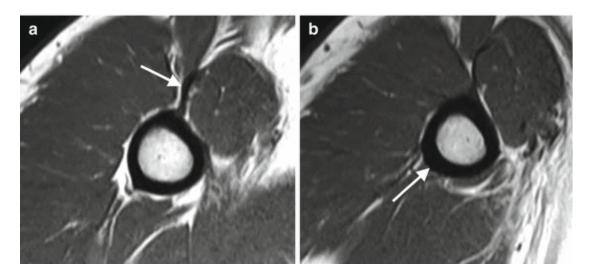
Insertion of pectoralis major tendon and inferior anatomic landmarks. Axial T1-weighted MRI show the normal aspect of pectoralis tendon insertion (arrow, a) at the lateral edge of the intertubercular groove, and also show
